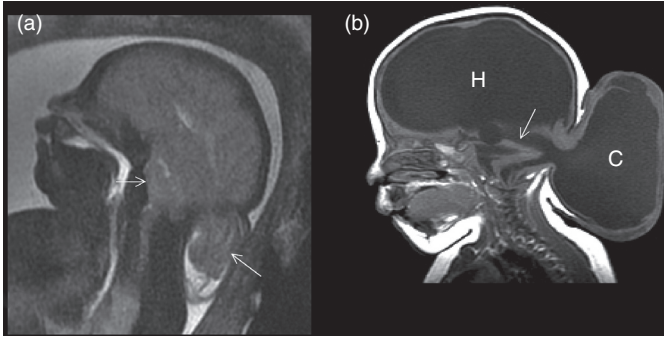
(a) Fetal sagittal T2 MRI, showing cervico-occipital cephalocele (posterior arrow), Chiari III malformation (anterior arrow), agenesis of the corpus callosum, and microcephaly. (b) Neonatal sagittal T1 MRI, showing occipital meningoencephalocele (C) with kinked brainstem (arrow) and hydrocephalus (H).
